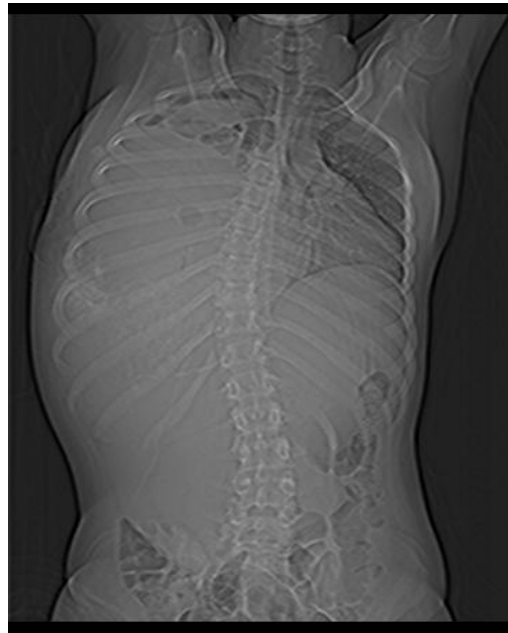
Plain chest image (CT scanogram) shows almost complete opacification of the right hemithorax, widened intercostal space, mediastinal shift to the left and inferior displacement of Right hemidiaphragm and liver inferiorly
